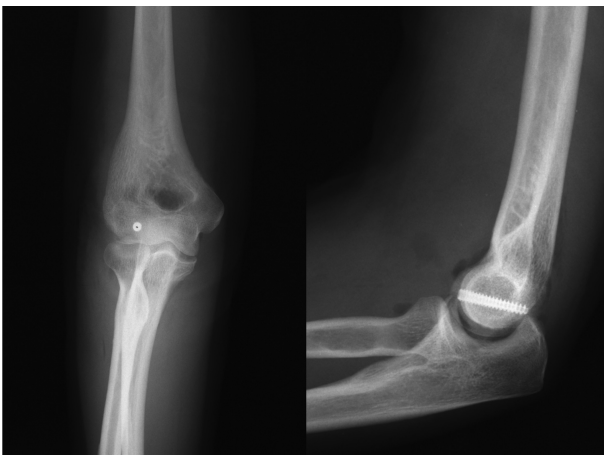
Postoperative X-ray after open reduction and internal fixation of the capitellar fragment using 1 Acutrak standard screw
